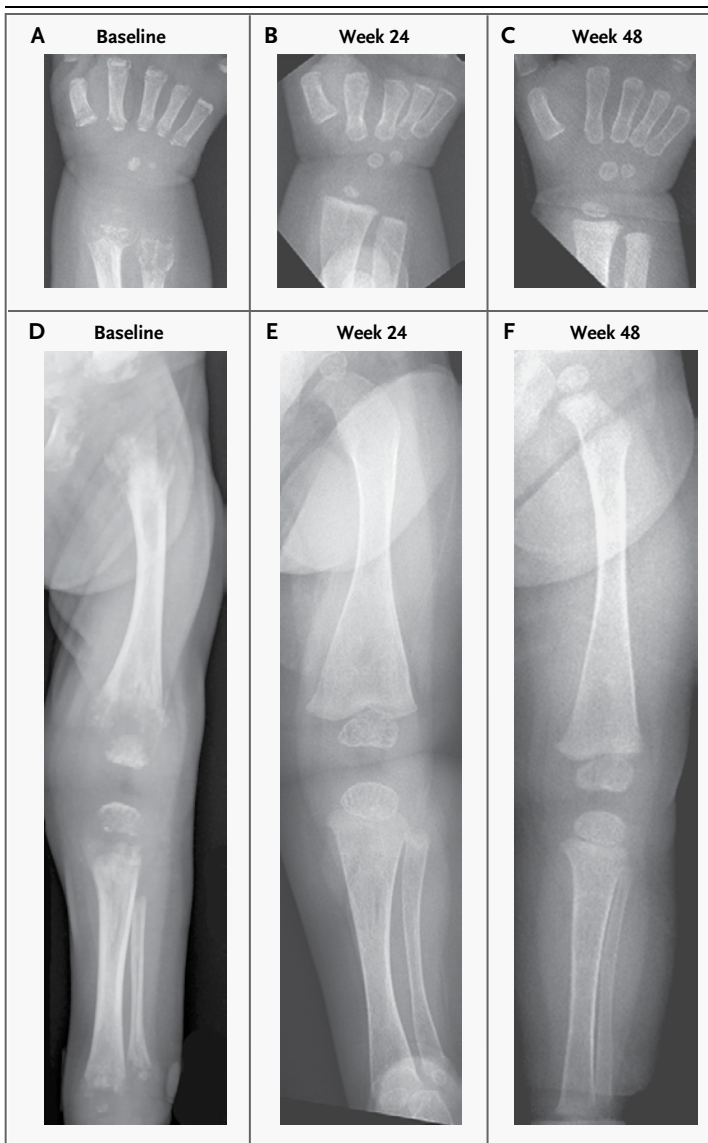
Radiographic Findings at Baseline and at Weeks 24 and 48 in Patient 2.
